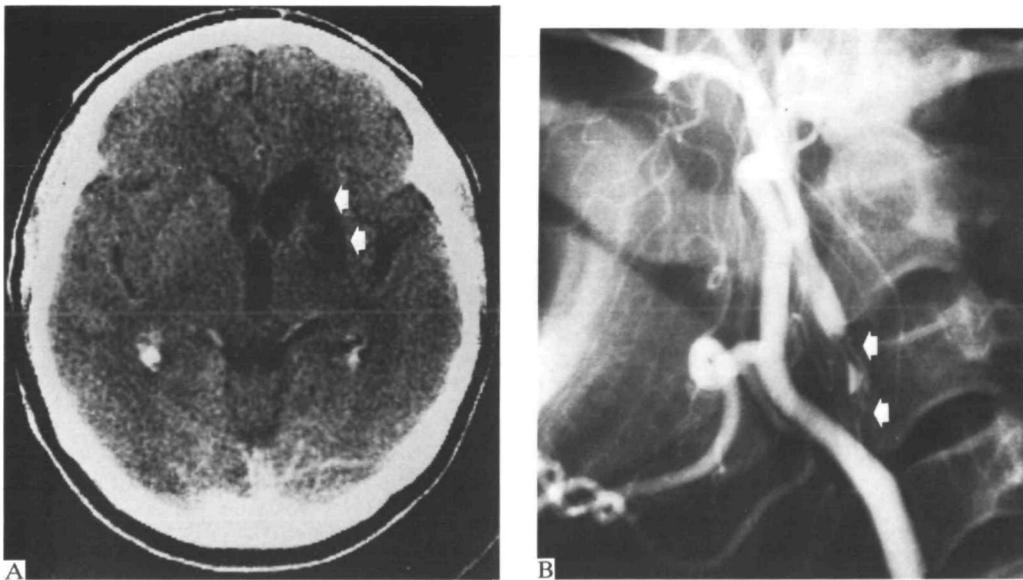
A, unenhanced CT scan showing left striatocapsular infarction (arrows). B, angiogram showing ipsilateral high grade internal carotid artery stenosis (arrows).
